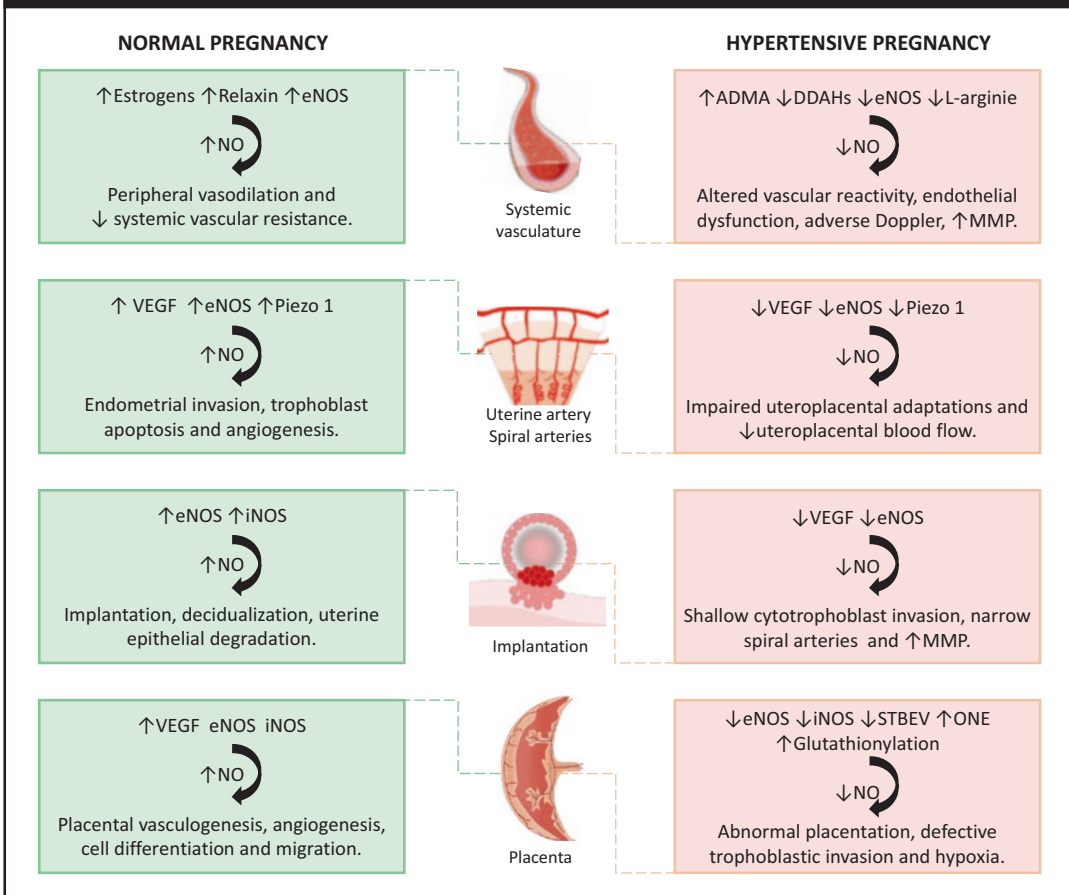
Evidence of nitric oxide impairment during hypertensive pregnancies. During a normal pregnancy, estrogens modulate the systemic arterial vasodilation by upregulating eNOS. The peptide hormone relaxin stimulates the formation of endothelin, increasing NO-mediated arterial vasodilation and leading to systemic vascular resistance fall. In hypertensive pregnancy, these vascular adaptations are impaired. In PE, asymmetric dimethylarginine (ADMA), an NOS inhibitor, is elevated, and dimethylarginine dimethylaminohydrolases (DDAHs), which stimulate ADMA degradation, is reduced, leading to impaired NO bioavailability. Additionally, L-arginine transport into human platelets, which is important to NO production, is reduced in PE. Consistent with reduced NO levels, augmented MMP-9 activity was found during hypertensive pregnancy. Concomitantly, altered vascular reactivity, endothelial dysfunction and adverse Doppler are found in PE. Pregnancy increases vascular endothelial growth factor (VEGF) in the uterus and upregulates the mechanoreceptor Piezo 1. VEGF stimulates angiogenesis and activates the eNOS-NO pathway and Piezo 1 leads to vasodilation by increasing NO release. NO plays an essential role in the endometrial invasion, trophoblast apoptosis and angiogenesis, supporting uteroplacental perfusion. PE is associated with eNOS abnormalities and decreased VEGF levels. Recent studies found an indication of NO pathway
